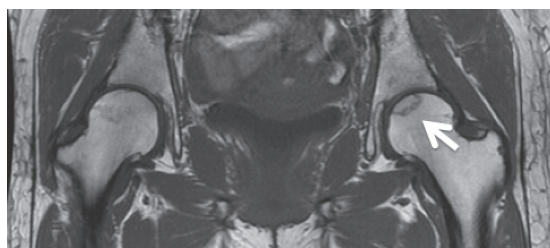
A T1-weighted image demonstrates a ring-like subchondral area of osteonecrosis (white arrow) present in the femoral head.
